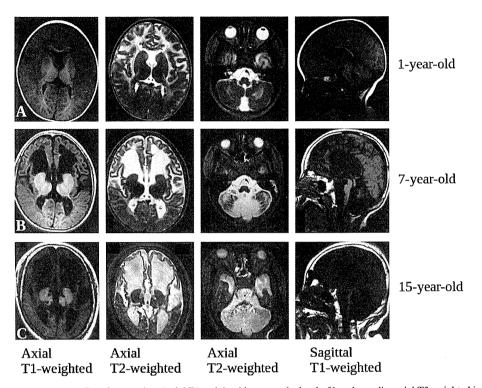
The rows A–C show MRI studies of our patient (axial T1-weighted image at the level of basal ganglia, axial T2-weighted image at the level of basal ganglia, axial T2-weighted image at the level of cerebellum, and mid-sagittal T1- weighted image), performed at age 1 year-6 months, 7 years-2 months, and 15 years-11 months. Cerebral white matter signal-intensity abnormalities (low T1-weighted and high T2-weighted) with frontal predominance involving the arcuate fibers, the external and the extreme capsule, and basal ganglia symmetric signal-intensity abnormalities involving mainly the caudate and putamen, are already apparent in A. Cerebellar white matter signal-intensity abnormalities are also noted in A. Frontal dominant cerebral white matter cavitation, cerebral and cerebellar white matter volume loss, and brain-stem and cerebellar atrophy are apparent in B. Cerebral and cerebellar white matter have almost vanished in C. Severe brain-stem, cerebellar, and cervical spinal cord atrophy are also noted in C.
